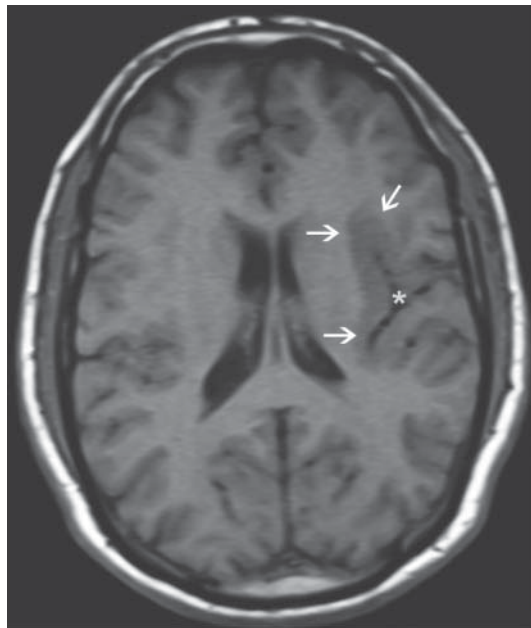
Axial T1 weighted MR image shows left temporo-parietal heterotopic gray matter (arrows) due to a closed-lip schizencephaly (asterisk)
